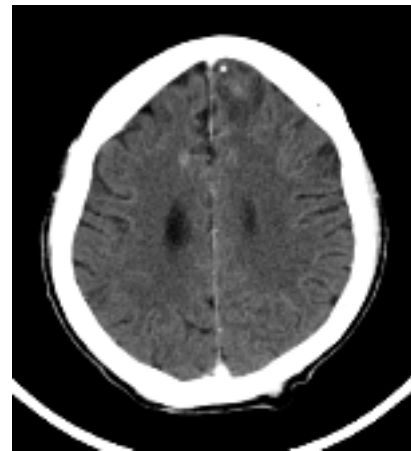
CT-Bild eines symptomatischen NCC-Patienten mit einem fokalen Ödem und einer isodensen Läsion in der weißen Substanz des linken Frontallappens [35]
